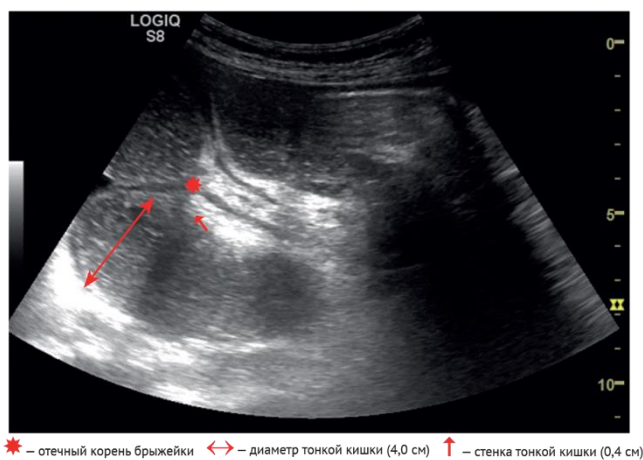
Ultrasonogram of patient G. with small bowel obstruction upon repeated admission
